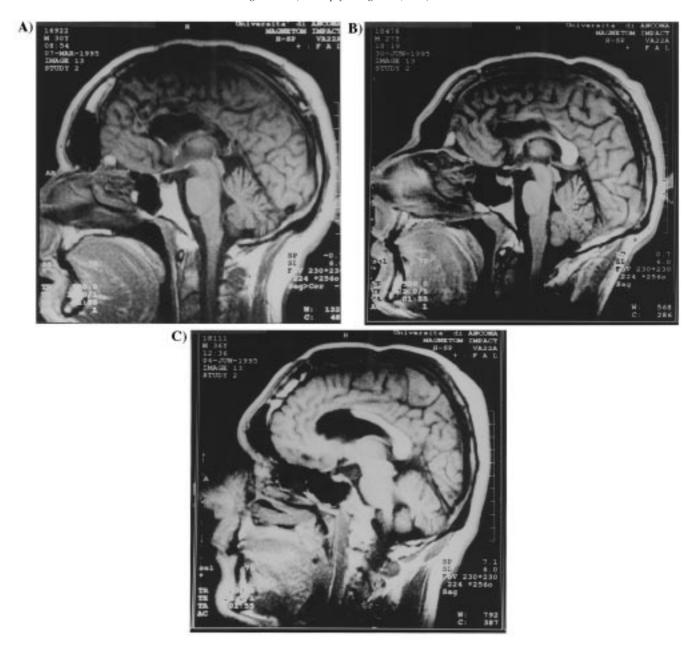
Magnetic resonance image (MRI) of: (a) one of the total callosotomy patients; (b) the patient with the largest anterior callosal section; (c) the patient with the smallest anterior section.
